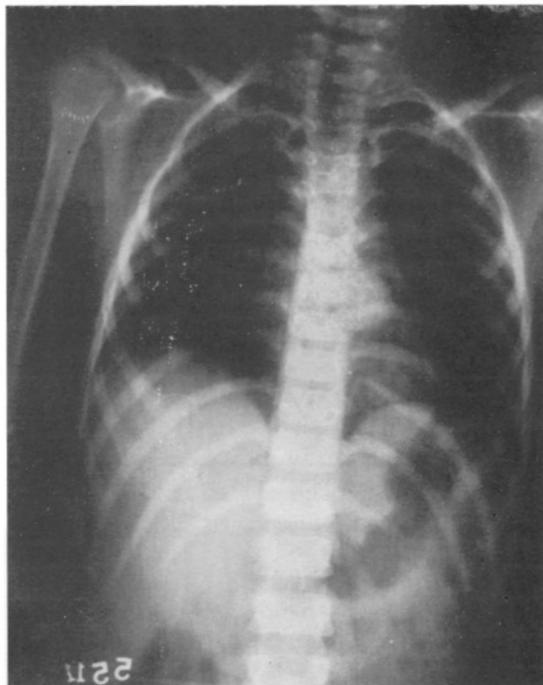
Chest x-ray showing mediastinal mass at thoracic 6-7 level.
